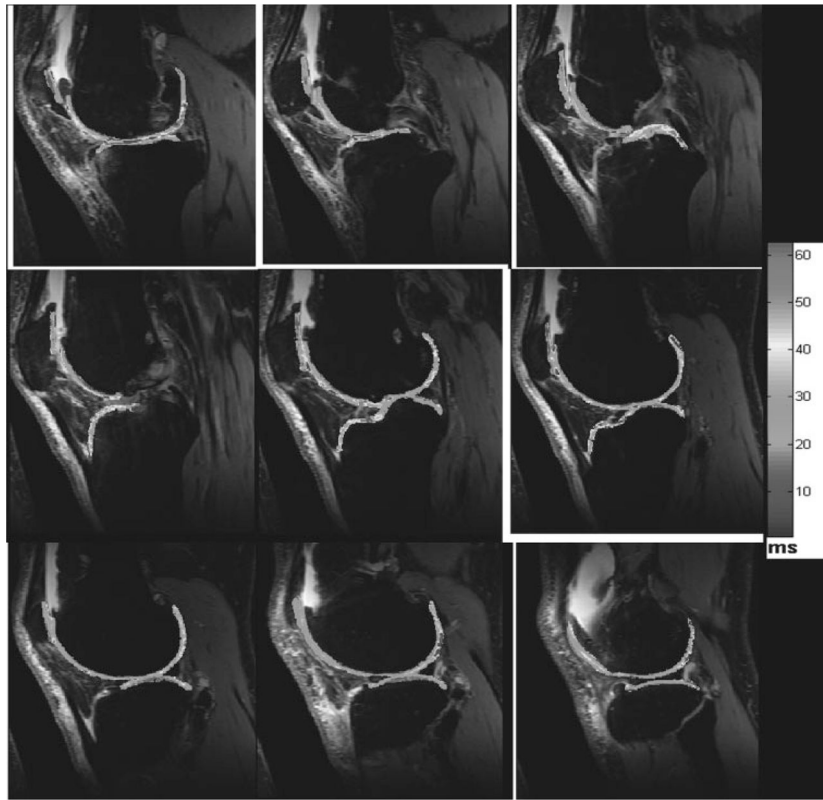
Series of representative two-dimensional-sagittal T2 maps computed from a patient with osteoarthritis. Two-dimensional-sagittal T2-weighted imaging parameters at 3 T are TR/TE, 4000/16.5, 33, 49.5, 66, 82.5; field of view, 15 cm \times 15 cm; matrix, 128 \times 256; bandwidth, 130 Hz; slice thickness, 1.5 mm; slice gap, 20%. The color bar scale represents the T2 values in milliseconds (color not shown). (From Wang et al, New York University, Department of Radiology.)
